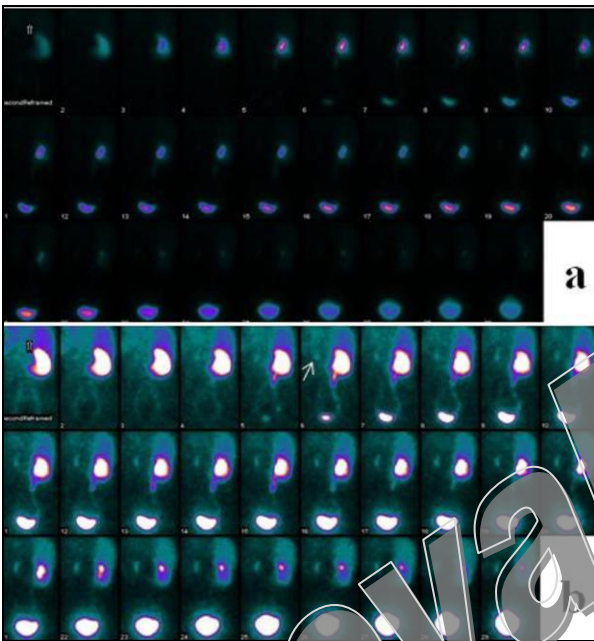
Concentration and excretion phase of the kidney in DTPA scintigraphy. Left kidney can not be seen in regular image (a), barely seen only in high contrast form with very late and minimal activity accumulation (arrow) in a small cortical region (b).
